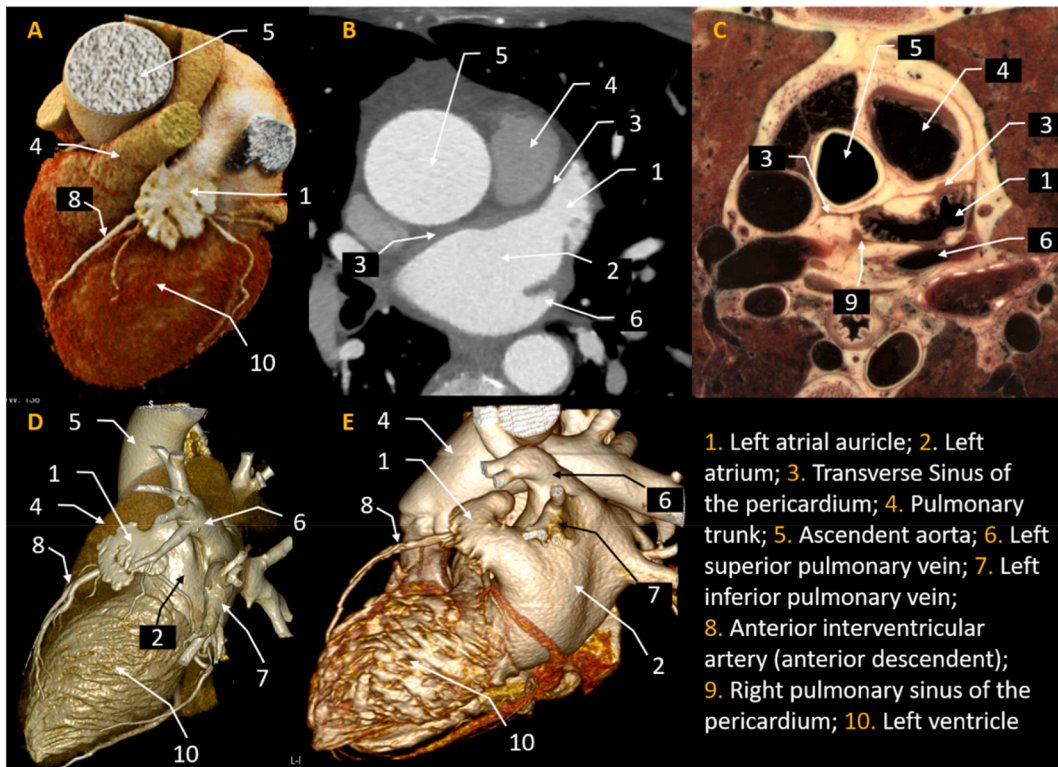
Cinematic rendering (A), Axial reconstruction (B) and Volume Rendering cardiac-CT images (D-E), highlighting LAA main features and its anatomical landmarks. Thoracic axial section through LAA obtained from Visible Human Server (C; courtesy of Prof. R.D. Hersch. Ecole Polytechnique Federale de Lousanne (EPFL). Switzerland. Visible Human Web Server. <http://visiblehuman.epfl.ch>).
